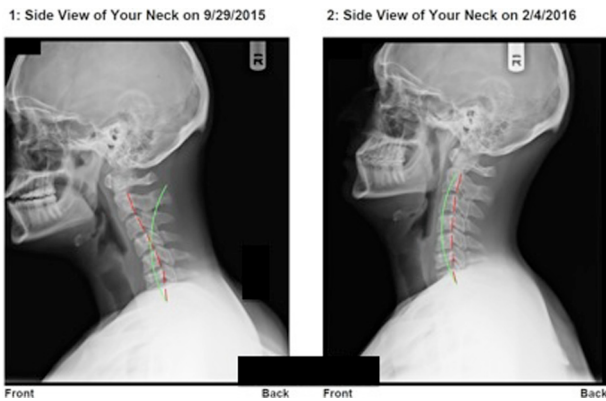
Lateral cervical radiographs
